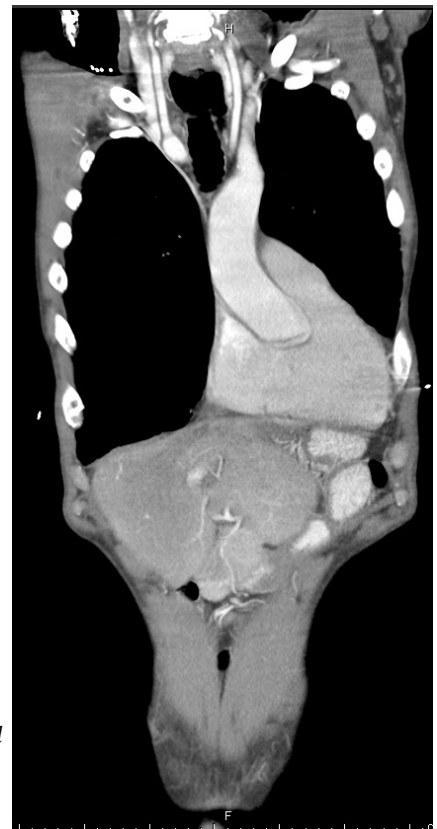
Computed tomography scan showing a dilated esophagus.
